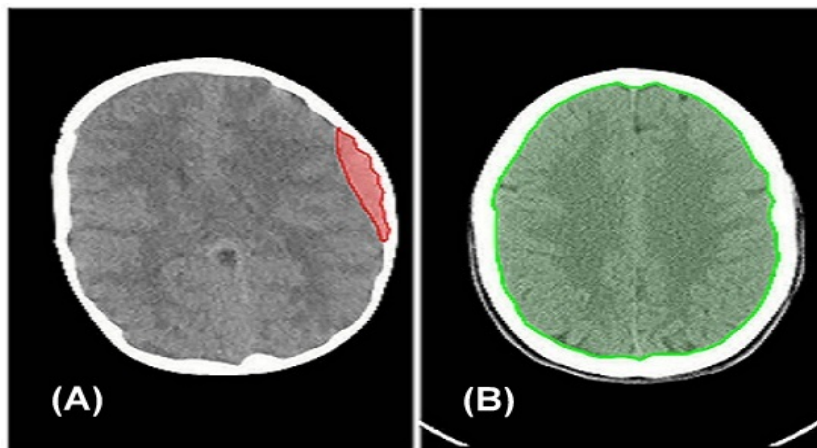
Successful Detection of (A) Hemorrhage and (B) Normal CT Scan.
